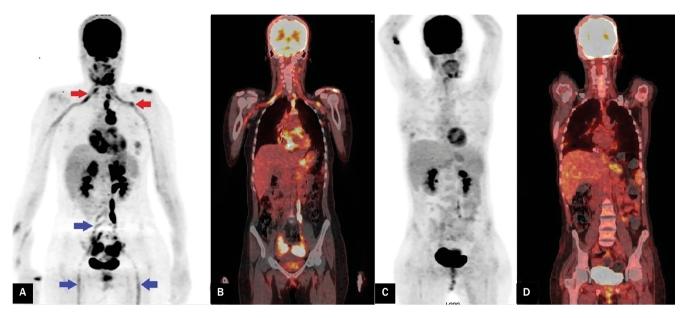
[¹⁸F]FDG PET/CT whole-body maximum intensity projection image (A) and coronal fused image (B) reveals linear abnormal uptake along the brachial plexus (reds arrows), and in both sacral plexus and the bilateral sciatic nerves (blue arrows); follow-up [¹⁸F]FDG PET/CT: whole-body maximum intensity projection image (C) and coronal fused image (D) shows complete resolution at these sites
